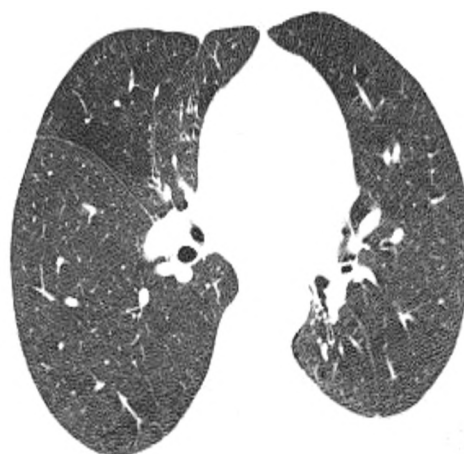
39-year-old female patient known case of Rheumatoid arthritis presenting with progressive dyspnea on exertion. (A) Axial HRCT image shows mosaic perfusion with areas of hyperlucency intermingled with areas of normal perfusion. HRCT diagnosis: Bronchiolitis obliterans.
